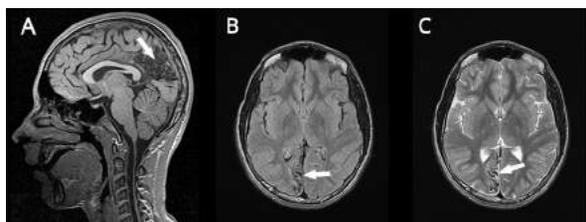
T1W in the sagittal plane (A), FLAIR (B) and T2W (C) images in the axial plane; White arrows indicate suspected abnormal leptomeningeal vessels in the right parasagittal, occipital region with focal atrophy of the surrounding cortex
